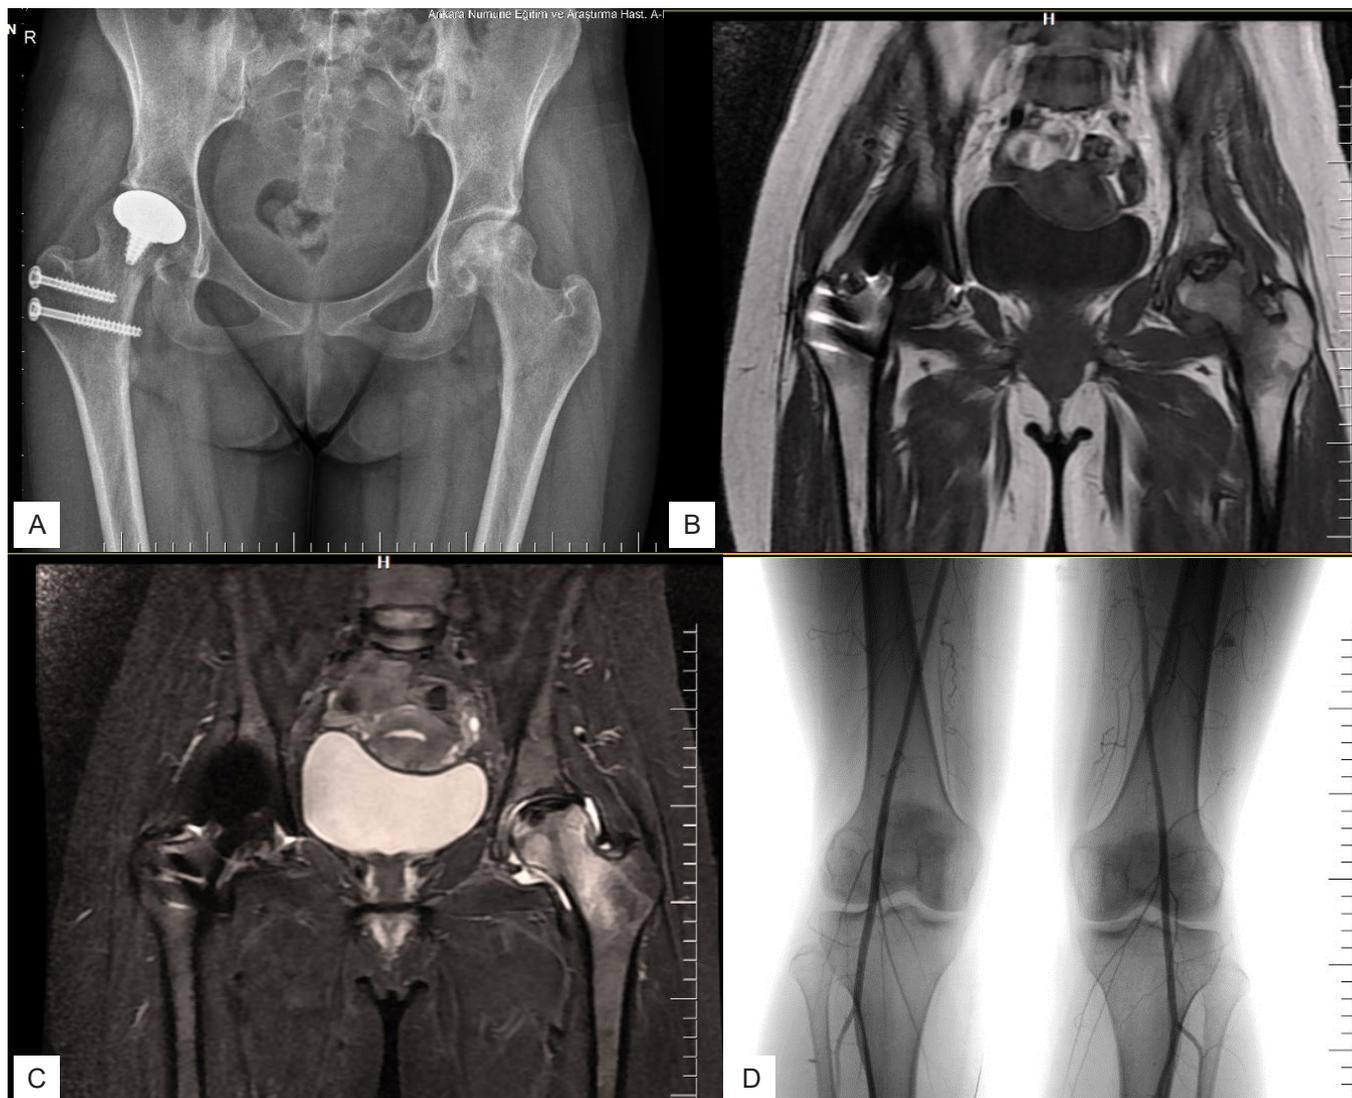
A 38-year-old female who had bilateral avascular necrosis of femoral head and underwent resurfacing arthroplasty on her right hip in another hospital, was admitted to our clinic with left hip pain. As a result of the examinations, the diagnosis of stage 2 avascular necrosis of femoral head was made in the left hip, and surgical treatment was planned with a vascularized fibular flap. (A) Plain radiograph of the pelvis, demonstrates cystic and sclerotic changes in femoral head, there was no collapse (B) Pelvis MRI, shows typical band-like pattern of avascular necrosis lesion in T1W and (C) in T2W (D) Lower extremity angiography, shows the intact peroneal arterial circulation.
